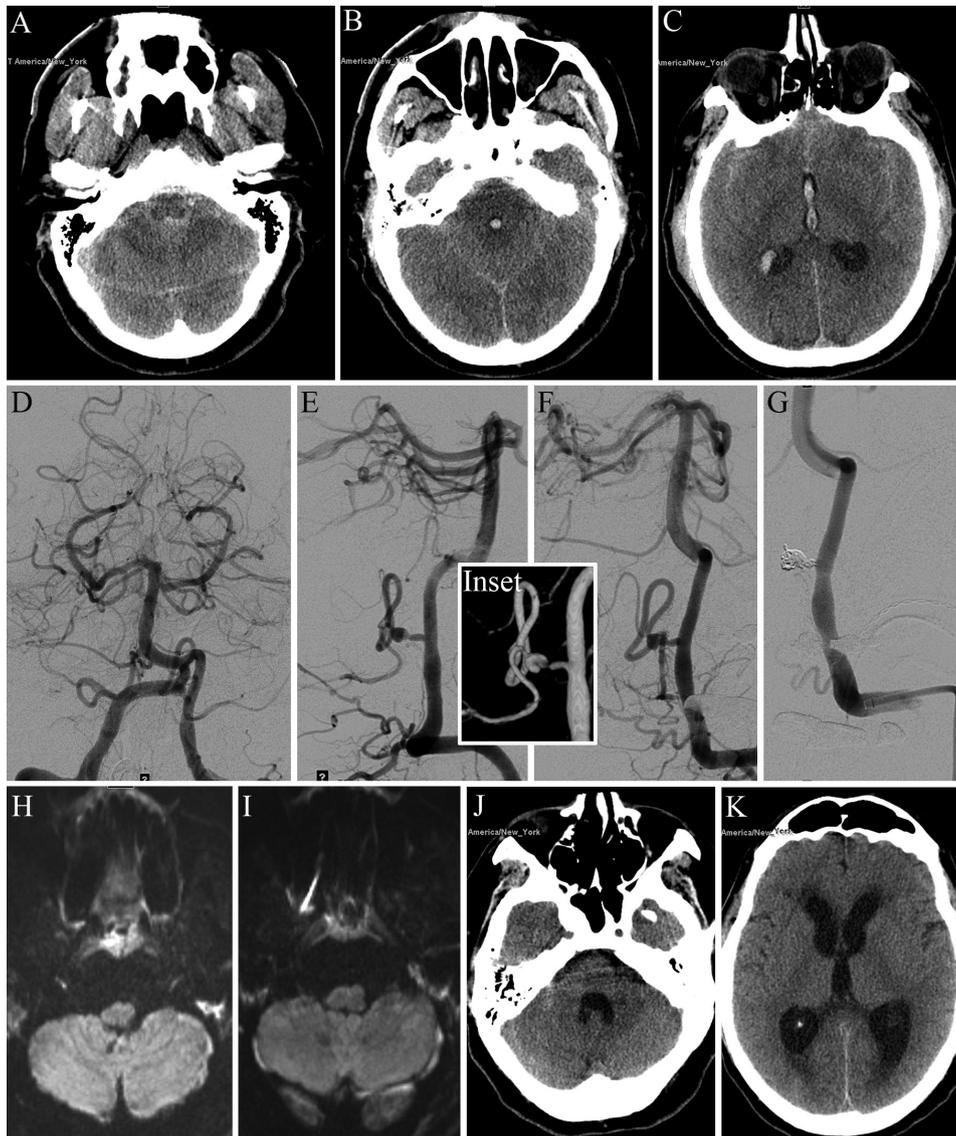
Case example of a patient who underwent anterior and lateral medullary segment posterior inferior cerebellar artery (PICA) sacrifice. (A–C) Axial non-contrast head CT showing perimedullary subarachnoid hemorrhage. Intraventricular hemorrhage is seen in the third and fourth ventricles with gravity-dependent layering of blood in the atrium of the right lateral ventricle. (D–F) Anteroposterior, lateral, and oblique angiograms showing a lateral medullary segment dissecting PICA aneurysm (inset: three-dimensional reconstruction). (G) Coil sacrifice of the anterior and lateral medullary segments of the left PICA. (H, I) Post-procedure day 4 MRI shows no cerebellar or medullary infarction. (J, K) Post-bleed day 12 CT shows failed external ventricular drain wean and communicating hydrocephalus.
